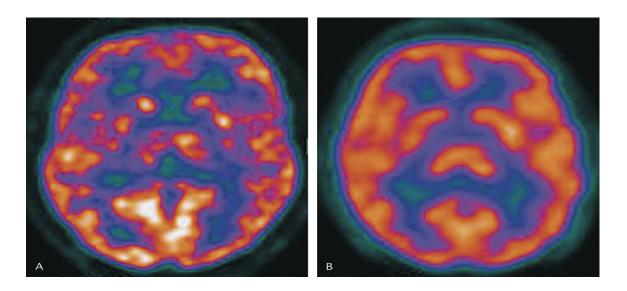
4 - A) FDG PET scan of a patient with history of cocaine abuse demonstrating an heterogenous radiotracer concentration in the cortex related to brain atrophy. (B) FDG PET scan of a normal patient.
